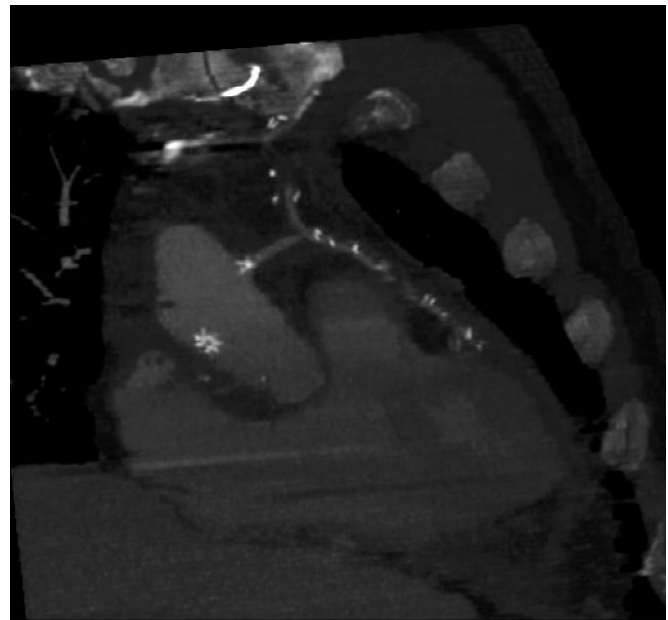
Patency control of grafts with multiple detector-row cardiac computed tomography, coronal reconstruction. The vein graft to the circumflex artery crosses the internal thoracic artery graft to the left anterior descending artery. Both grafts show the same opacification compared with the ascending aorta.
